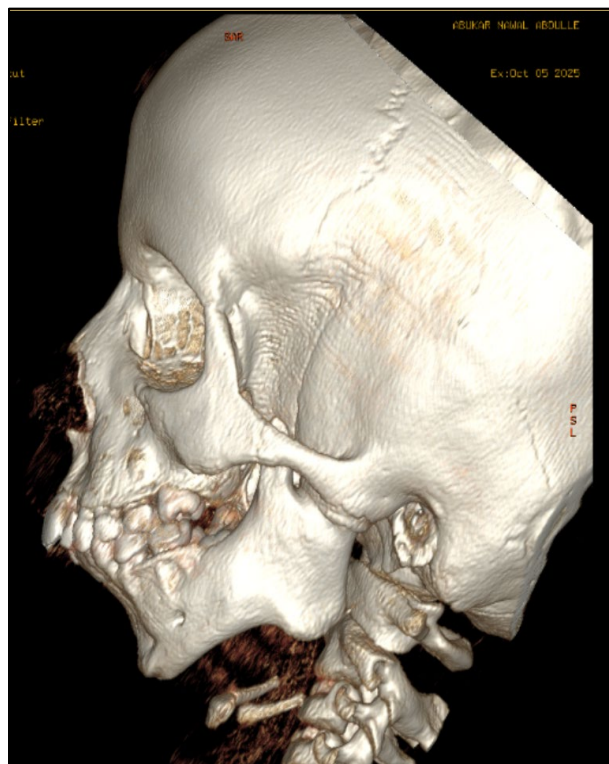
3D CT image showing chin deviation toward the affected side.
